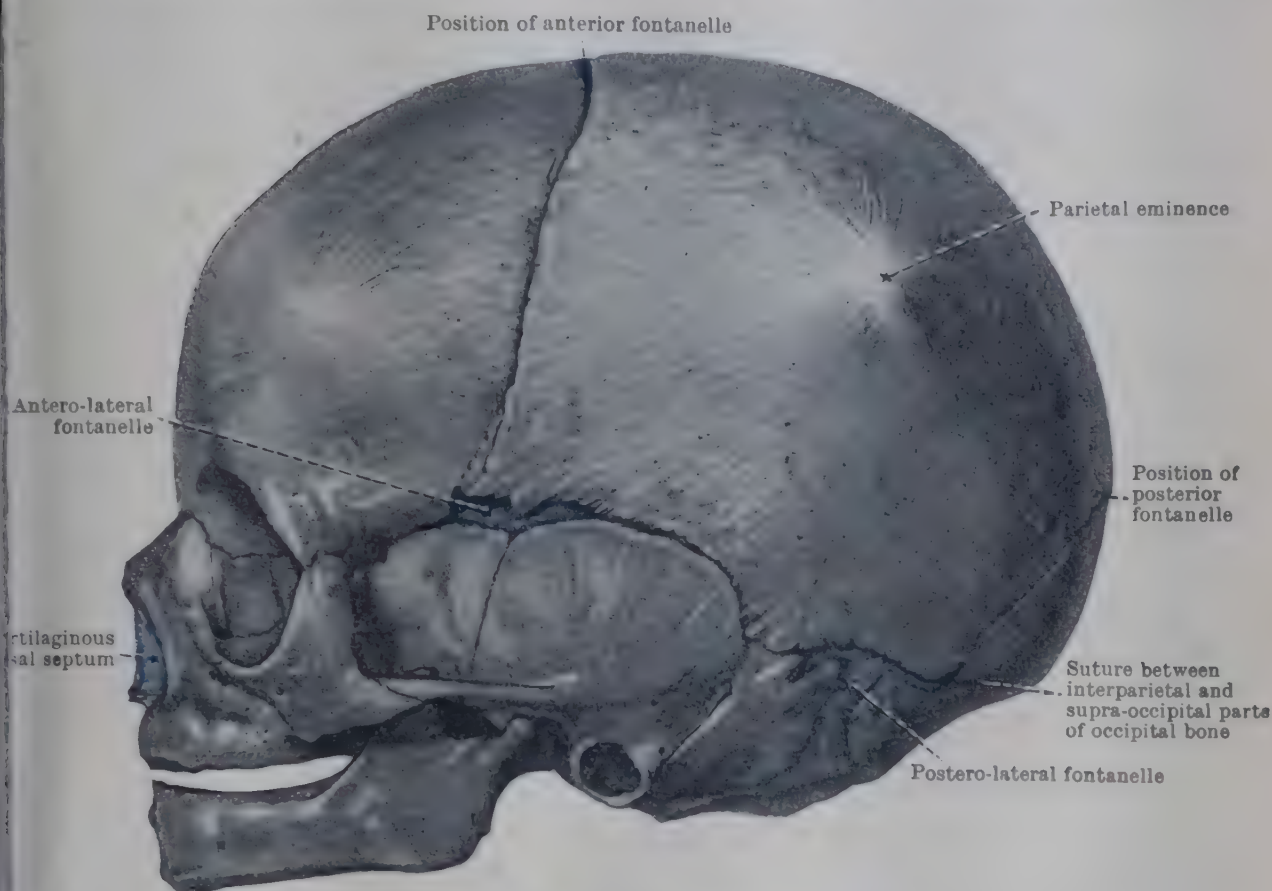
LATERAL ASPECT OF SKULL AT BIRTH. (Cf. Pl. V, Fig. 2, p. 150.)
